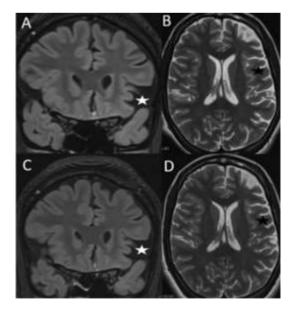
A) FLAIR Coronal & B) Axial T2 W image showing left frontal and perisylvian cortex atrophy (star) C) FLAIR Coronal & D) Axial T2 W image showing no progression of left frontal and perisylvian cortex atrophy (star) at 13 month follow up (case 8) (1)
